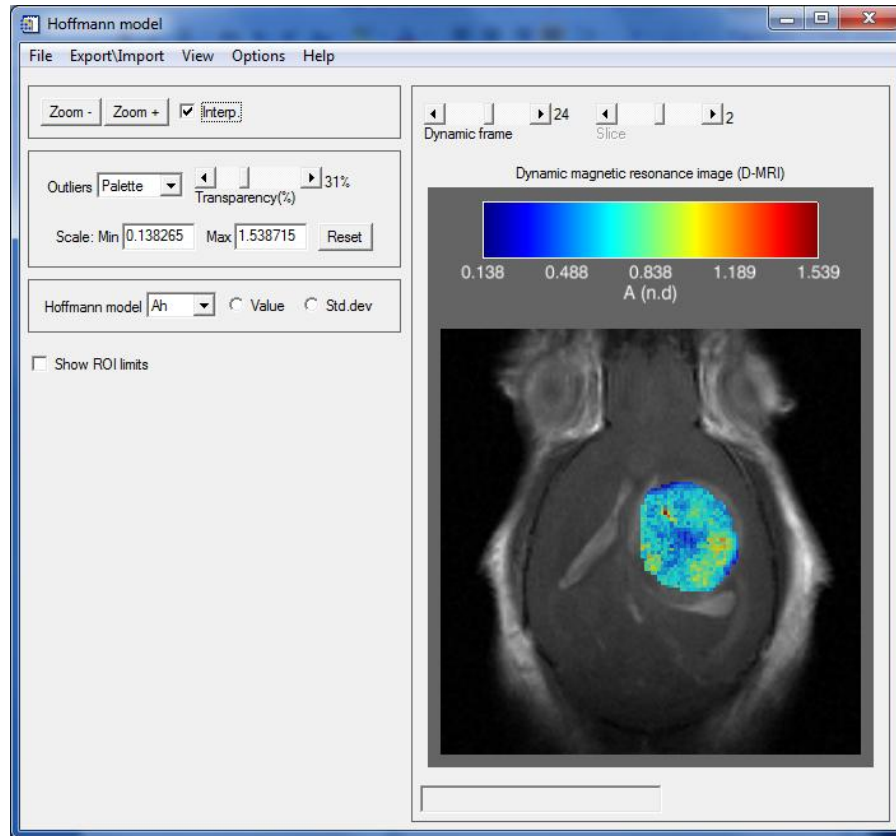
Results window with colormap of analyzed ROI superimposed over the DCE-MRI frame
